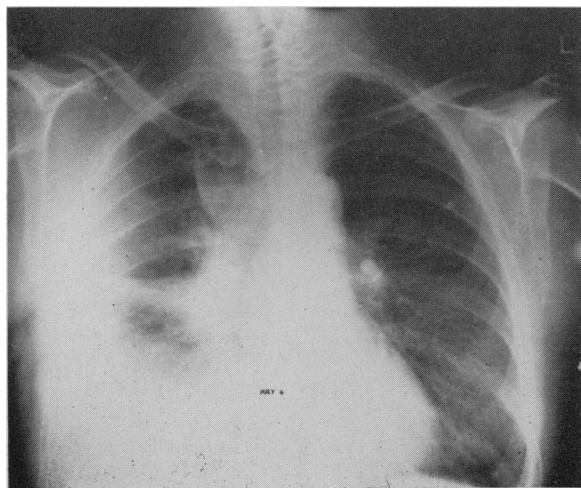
Chest radiograph taken at the conclusion of radiotherapy. A right-sided pleural effusion is present. The tumour mass is smaller.
